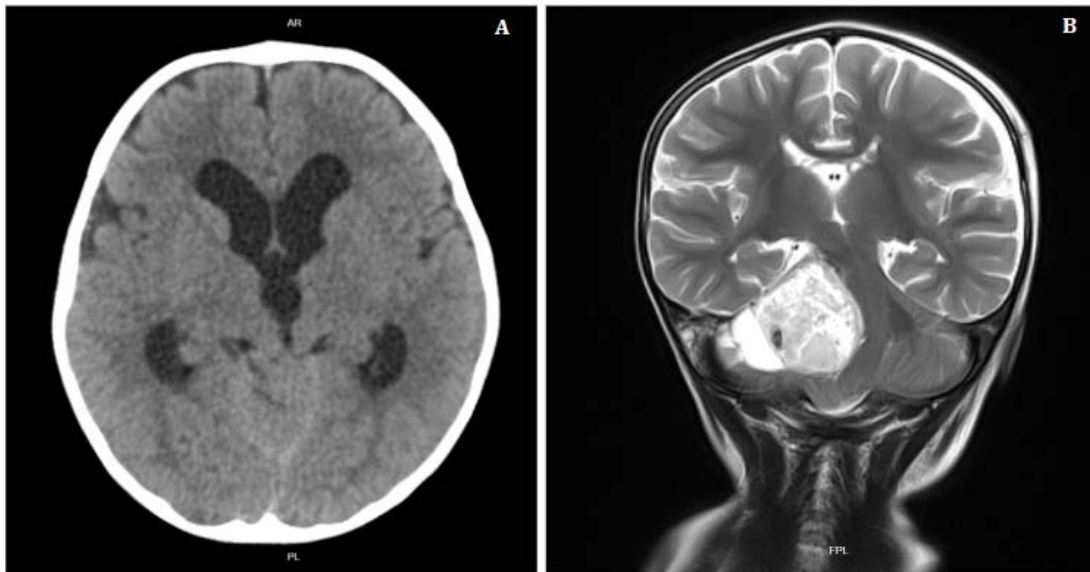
2-year-old male with medulloblastoma. FINDINGS: Axial (A) and Coronal (B) Brain MRI with tractography (A) and Nuclear MRI (B) that shows an extra-axial mass, well-defined in the cerebellopontine angle cistern, hypointense on T1, hyperintense and heterogeneous on T2 with multiple hypointense foci in the susceptibility sequence, and with an area of intrinsic hyperintensity on T1 towards the periphery of the lesion due to bleeding at different stages of evolution. It occupies and expands the internal auditory canal, presents heterogeneous enhancement, and exerts marked compressive effect on the pons and the right cerebellar hemisphere with almost total obliteration of the 4th ventricle. It measures 40.7 x 56.9 x 33 mm. TECNHIQUE: 1.5T equipment. Radiofrequency pulse sequences with techniques including SE, TSE, FE, or IR. These images evaluate the longitudinal and transverse relaxation times of tissues in a multiplanar manner. Source: Patient’s medical chart, 2023.
